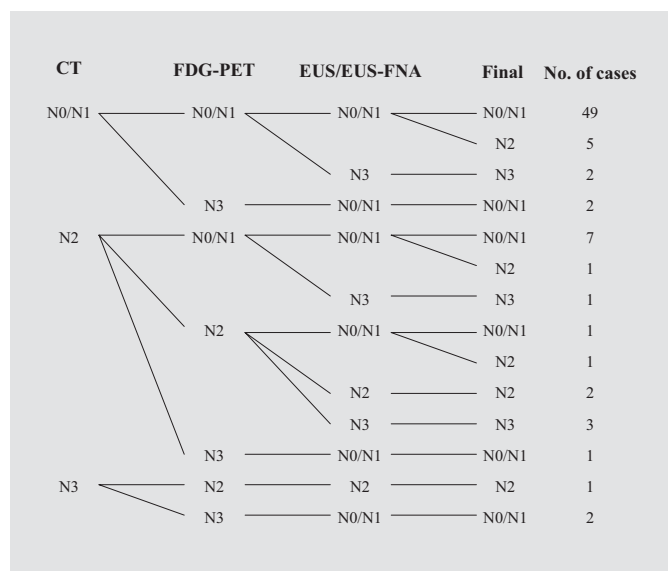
The raw data of the N-staging in the 78 patients based on the CT, FDG-PET and EUS/EUS-FNA findings.
